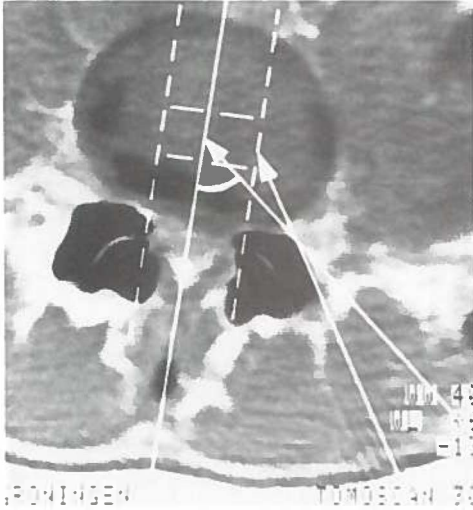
CT scan in the plane of disc level L4-L5. Two needle placements are outlined: one with the tip of the needle in the exact centre of the nucleus, the other just in the margin of the nucleus.
